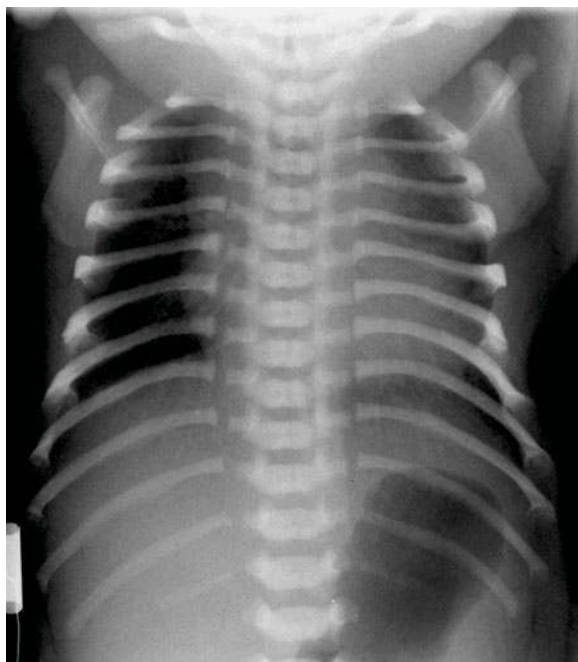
Chondroectodermal dysplasia (Ellis-van Creveld). The boy was born at 28 gestational weeks. Death occurred after 1 h. Clinical examination showed a narrow chest, short extremities, small nails, and polydactyly (pre- and postaxial). The postmortem radiograph shows short ribs, small ilia with horizontal acetabula and small sacrosiatic notches. The tubular bones are short with spurs extending longitudinally at the metaphyses of the distal femora. The metaphyses otherwise are smooth. The spine is normal. Autopsy revealed small lungs and bicuspid aortic valves. Image courtesy of Dr. Eklöf, Stockholm
